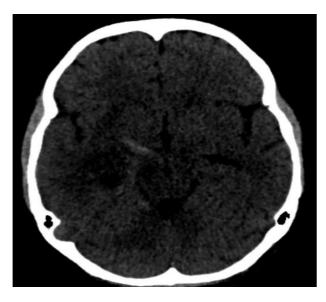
Computed tomography of the skull without contrast demonstrating hyperdensity of the right internal cerebral vein (hyperdense vein sign) in the non-contrast acquisition, in addition to thalamocapsular hypoattenuation representing an area of local infarction.
